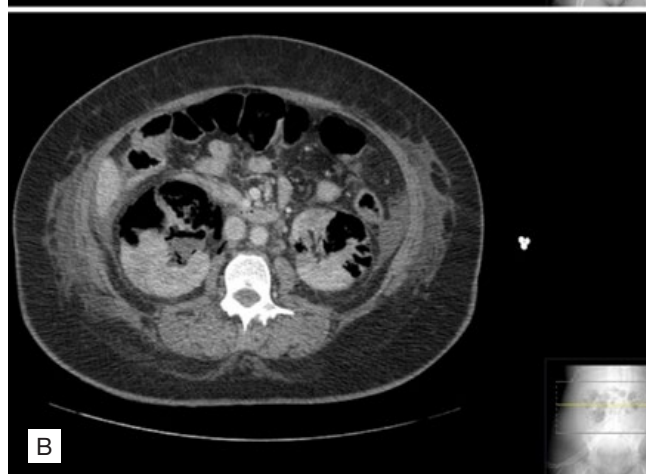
A and B: CT abdominal scan showing enlargement of the bilateral kidney gas areas with perirenal extension and parenchymal destruction.
